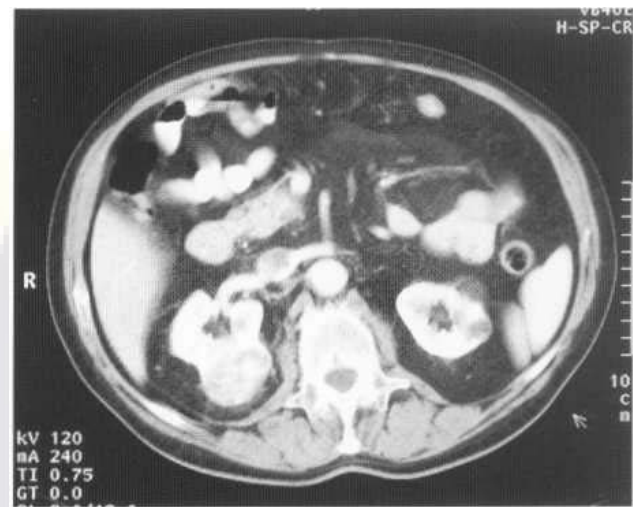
Stage II renal cell carcinoma on postcontrast CT. The tumour extends to the margin of the kidney and shows some local nodular extension through the renal capsule.
